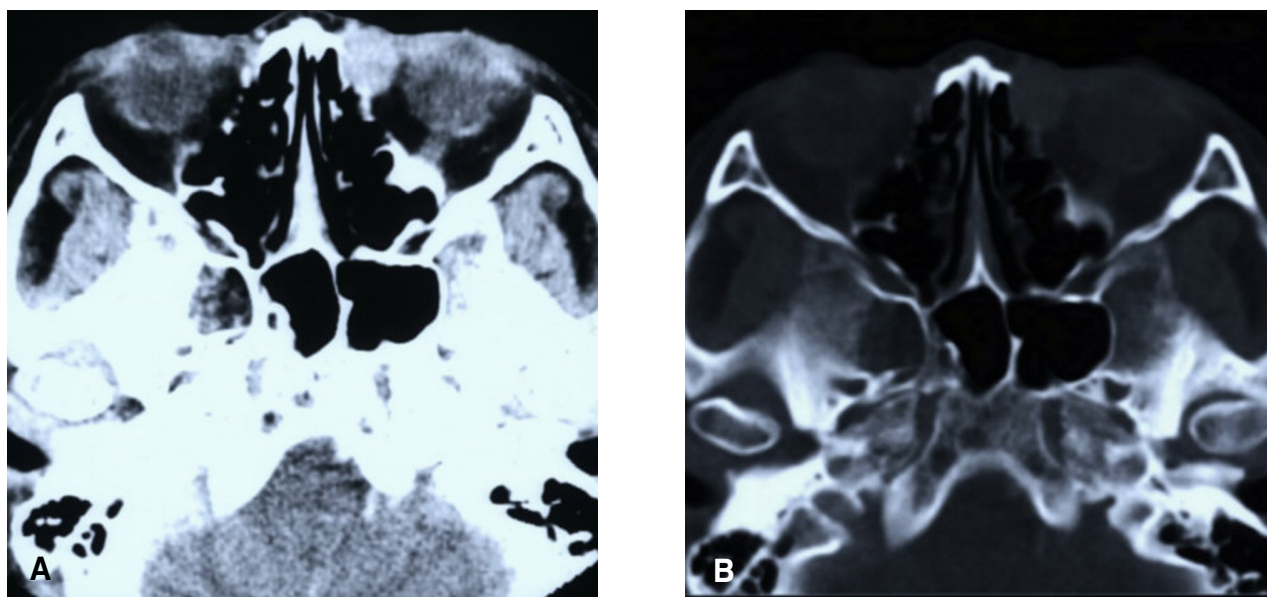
CT findings of melanoma of the left lacrimal sac. A) Contrast enhanced axial CT scans show a well enhancing soft tissue mass in the left nasolacrimal fossa. B) There was no evidence of destruction of adjacent bony structures.
